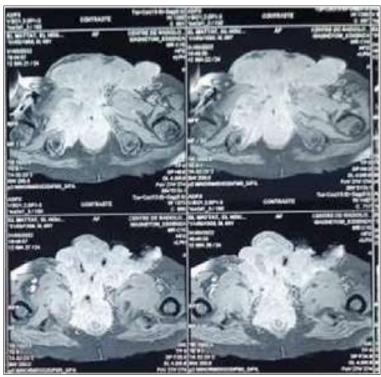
MRI showing a bulky aggressive tumor infiltrating the bilateral pelvi perineal and inguino scrotal region with right inguinal ADP
